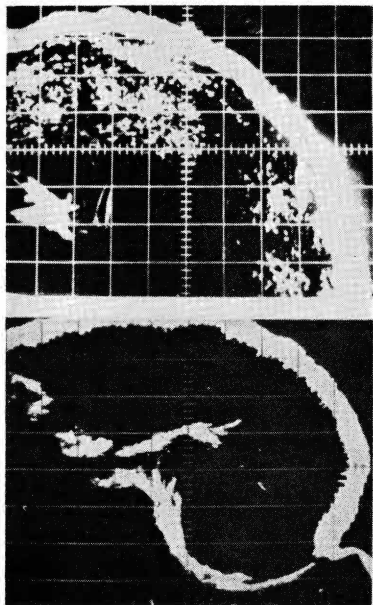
The lower sonogram is the liver region in a healthy laboratory worker, and the upper sonogram the corresponding liver area in a patient with alcoholic cirrhosis. Reprinted from *Biomedical Science Instrumentation*. Vol. 2. New York: Plenum Press, 1964, p. 11.
